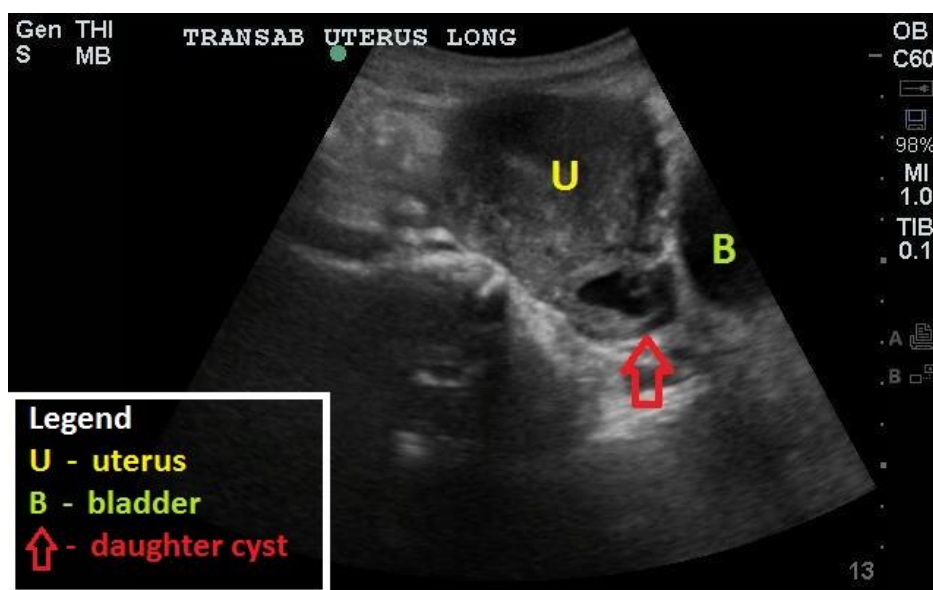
Point-of-care transabdominal ultrasound demonstrating the uterus and daughter cyst in the sagittal plane.
